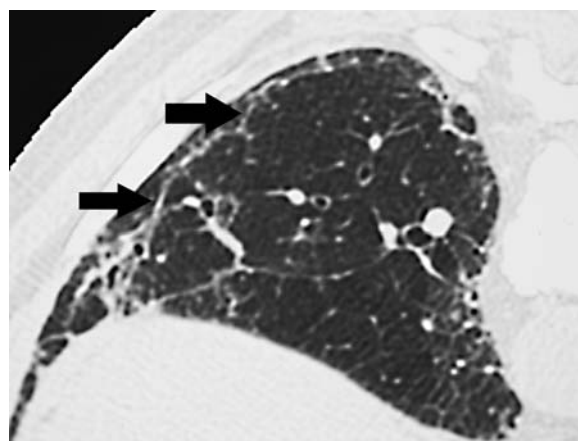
Prone thin-section computed tomography of an individual with early asbestosis showing a subpleural curvilinear line (arrows)
